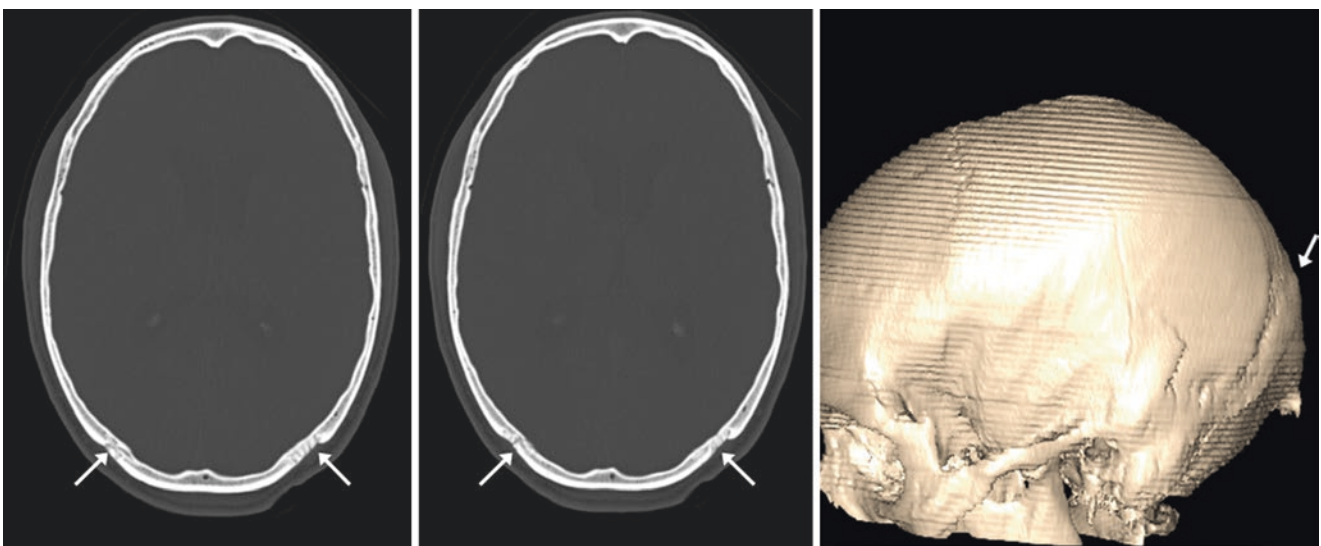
A 29 year old with mild bathrocephaly and mild protrusion of the occipital bone past the adjacent parietal bones with step-off (*arrows*), as depicted on axial sequential NECT images (*left and middle*), and on a 3D VR lateral view (*right*). The step-like artifacts on the 3D reconstruction were obtained from reconstruction of a sequential CT acquisition
